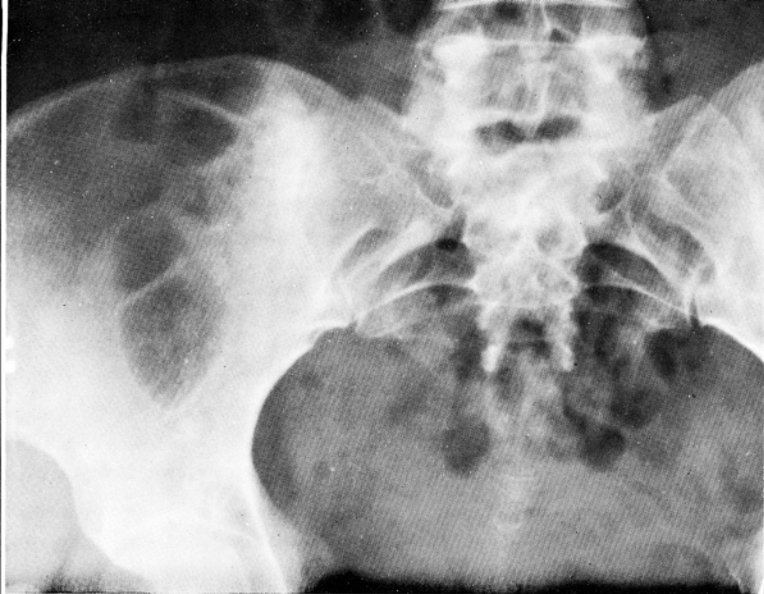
Roentgenogram taken in 1963 showing only a slight increase in bone density in the right sacro-iliac area.
